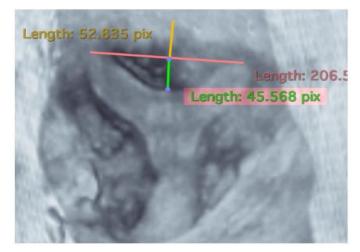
Three-dimensional ultrasound showing uterine wall thickness in yellow measuring approximately 5.3 mm and internal indentation in green measuring approximately 4.5 mm. Thus, according to ESHRE-ESGE classification, the internal indentation is more than 50% uterine wall thickness and therefore this fall under the category of partial Septate uterus. However, according to ASRM criteria, the internal indentation is less than 1 cm and therefore this is a normal/Arcuate uterus.
